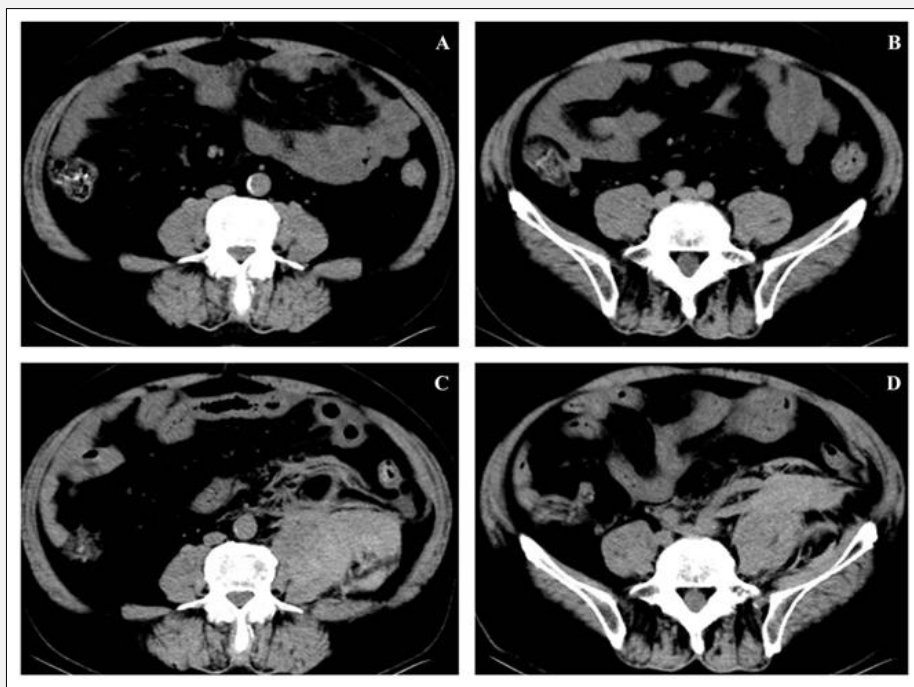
Abdominal CT findings during hospitalization.
